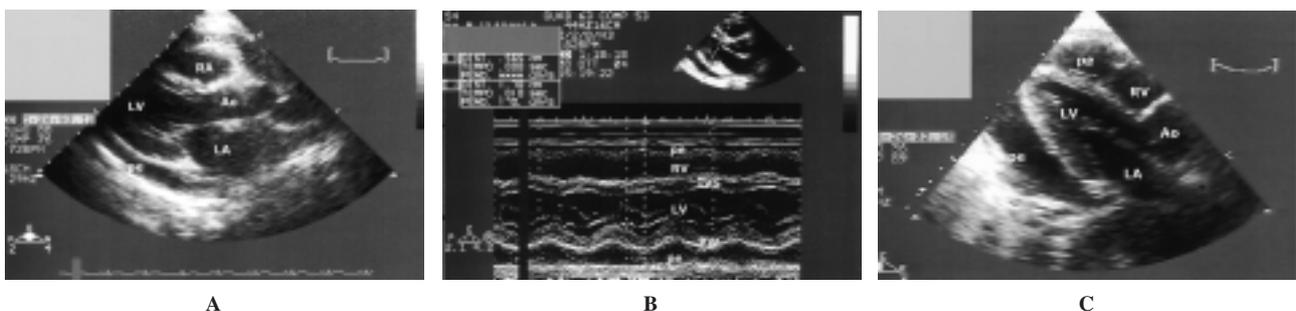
Evaluation of pericardial effusion (pe) by means of echocardiography. Panels A and B: severe pe according to the Weitzman criteria (echo-free space [anterior plus posterior] 23 mm as measured at the end of diastole) with evolution to cardiac tamponade with a swinging heart (panel C). Ao = aortic valve; IVS = interventricular septum; LA = left atrium; LV = left ventricle; PW = posterior wall; RA = right atrium; RV = right ventricle.
